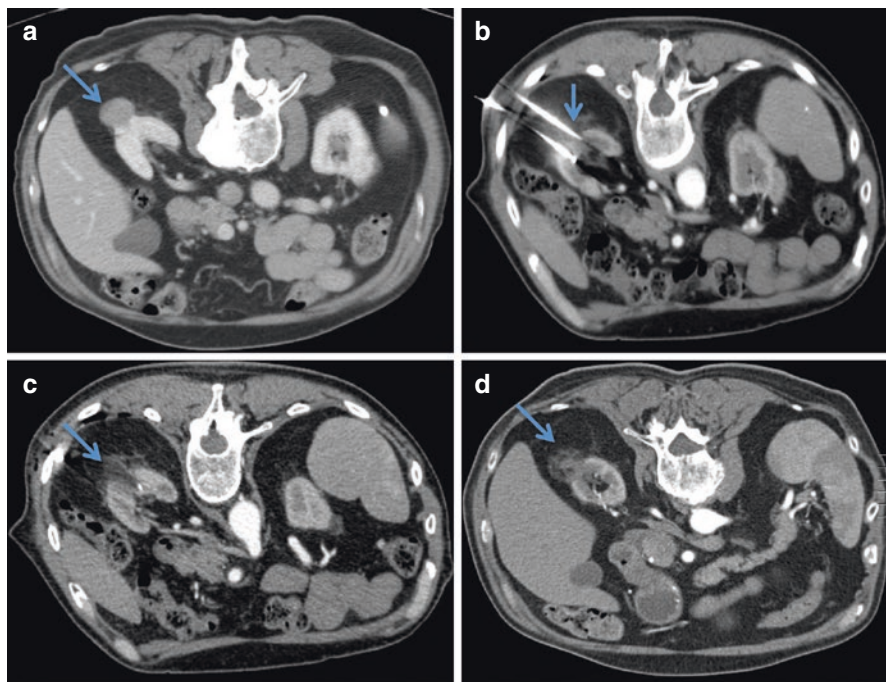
Example of a small renal mass treated with percutaneous cryoablation. (a) Preoperative CT scan with enhancing right-sided small renal mass, (b) placement of cryoprobes, (c) hypodense ablation zone corresponding to iceball, and (d) follow-up CT scan showing no residual disease as there is no enhancement
